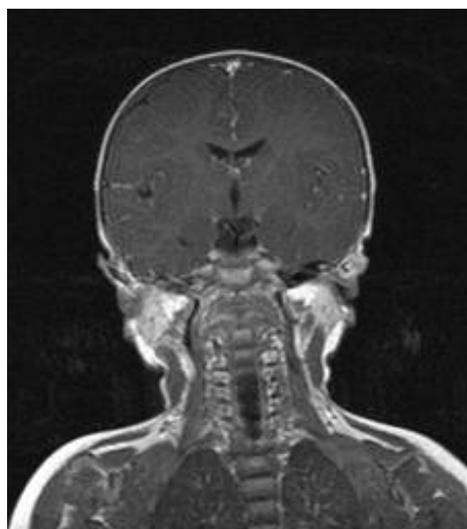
Skull and neck MRI – normal.
